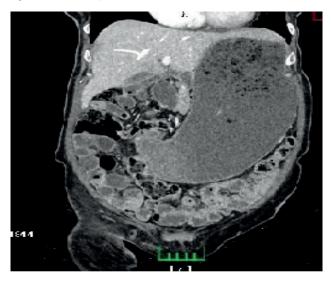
Coronal plane of the stomach on abdominal CT
